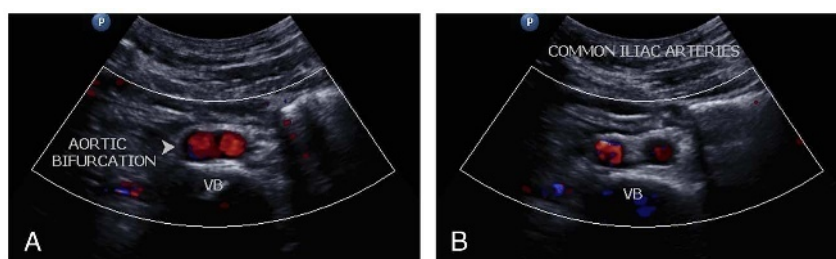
A, Transverse sonographic image showing the iliac vessels just as they bifurcate from aorta. B, The iliac vessels after they bifurcate. VB indicates vertebral body.
